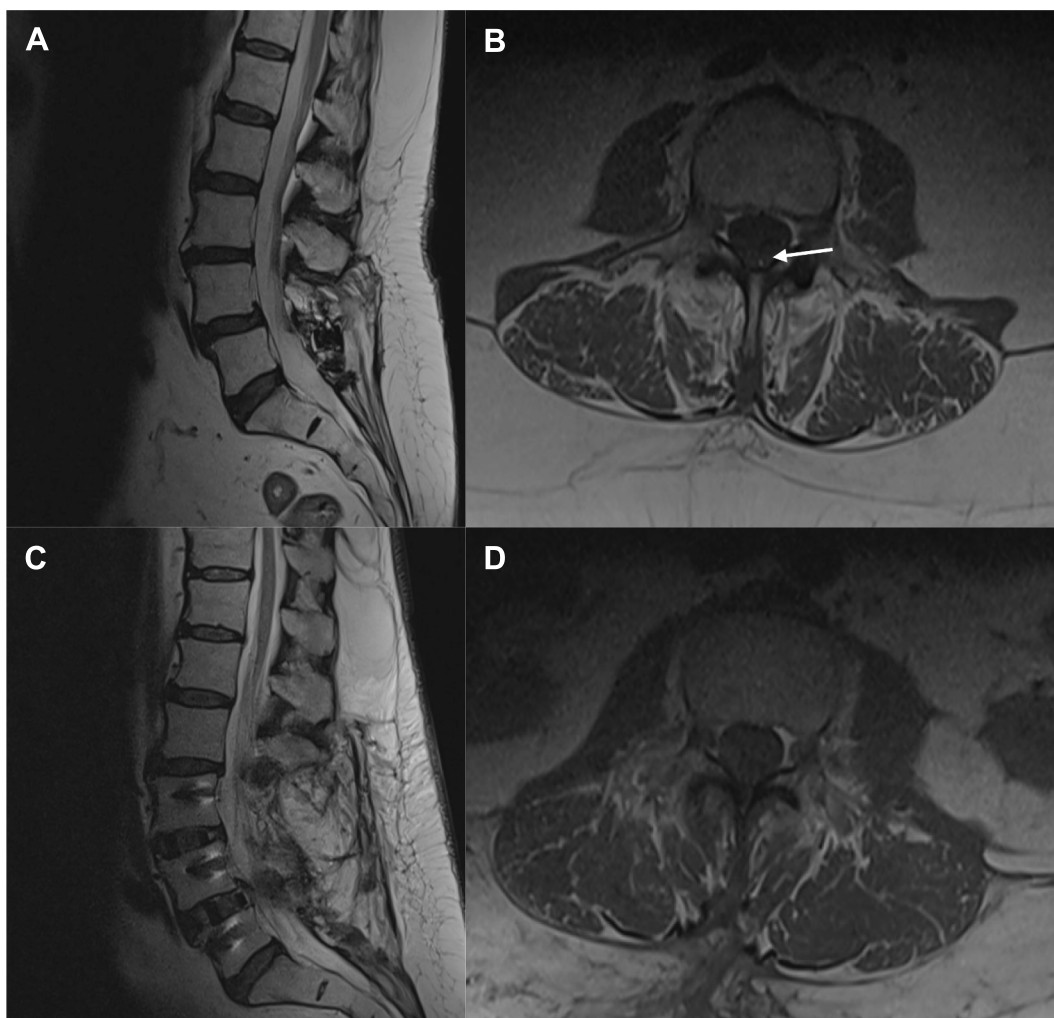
Representative Case #1. 67F with fatty filum terminale and symptoms of tethered cord syndrome presents following previous L4-5 posterolateral fusion. Preoperative (A,B) and postoperative (C,D) midsagittal T2-weighted and axial T1-weighted MRI demonstrating degenerative stenosis, prior L4-5 posterior defect, and fatty filum terminale (arrow). Postoperative imaging is following detethering (procedure 1) and multilevel lateral interbody fusion at L3-L5 with placement of posterior percutaneous segmental instrumentation (procedure 2) as described in the case vignette.
